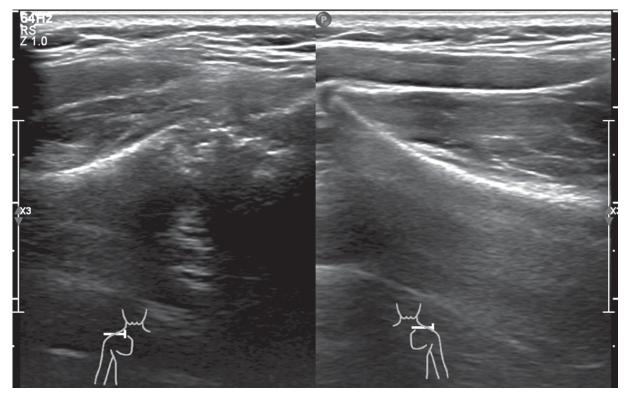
Comparative ultrasound images on split view of the left and right scapula. Irregular margin of the left scapular spine (left image); normal margin of the right scapular spine (right image)
